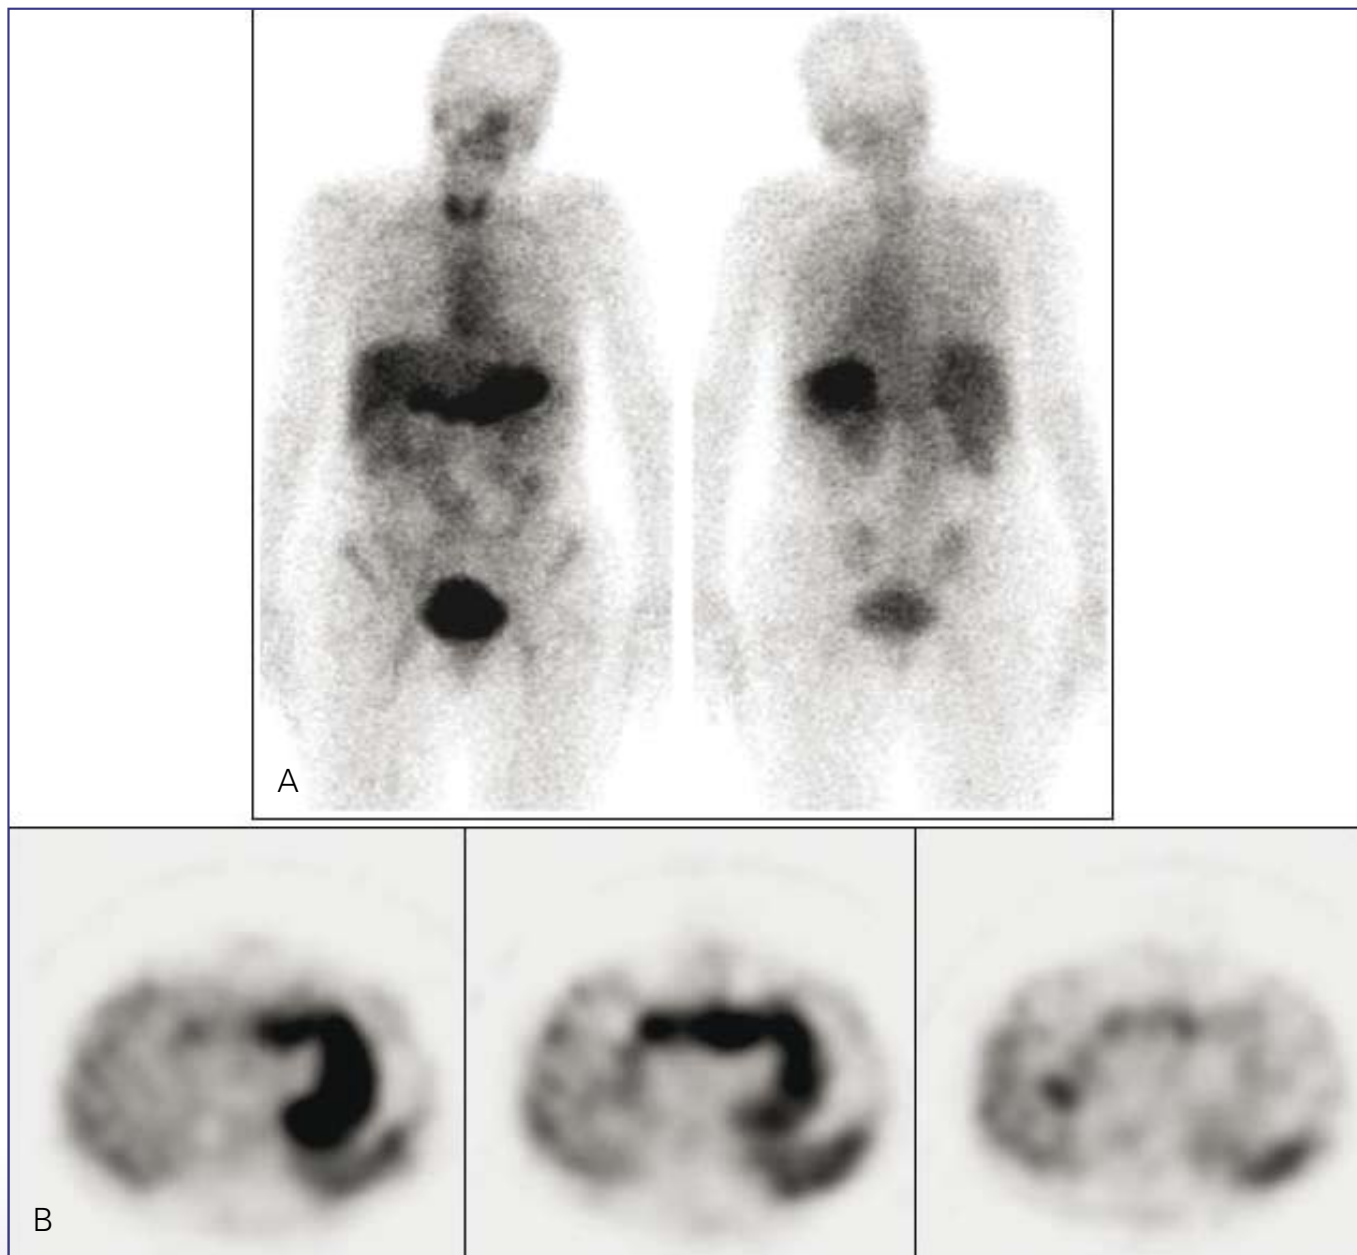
(A) Planar SAP scan image (anterior / posterior) of a patient with AA Amyloidosis; the spleen is difficult to assess because of uptake in the stomach. (B) SPECT/CT images conclusively show physiological uptake in the stomach and positive uptake (1+) in the spleen.
